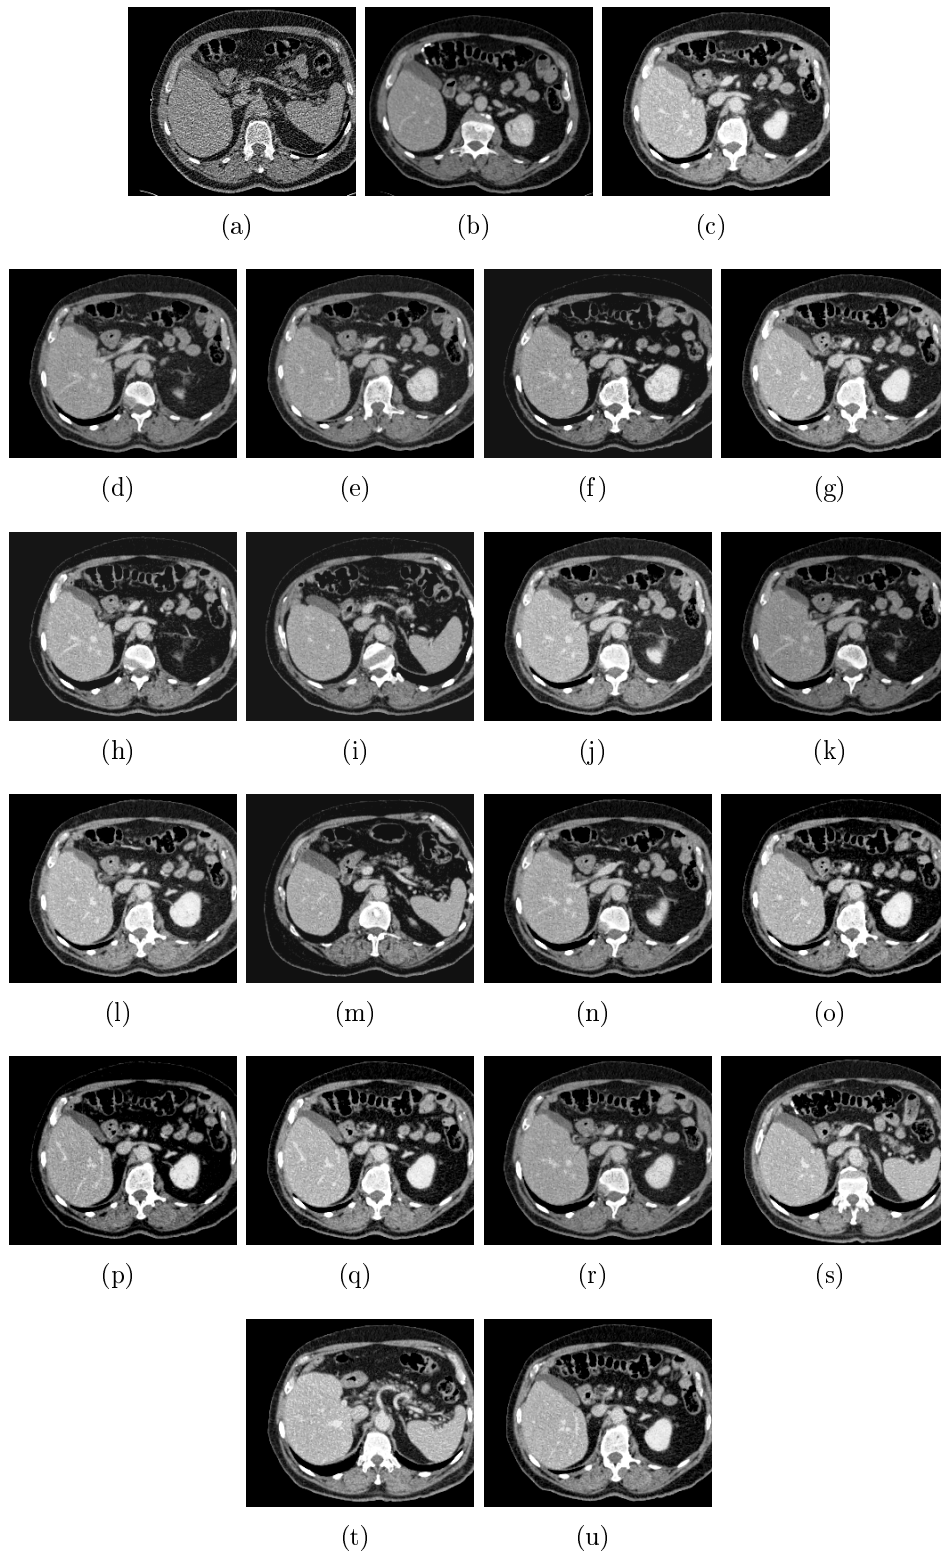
M-estimator: (a) represents the CT-fluoro slice. (b) represents the initial pose in the volume. (c) represents the estimated minimum (note that the spleen is not captured). From (d) to (u): the 2D views represent CEPs.
